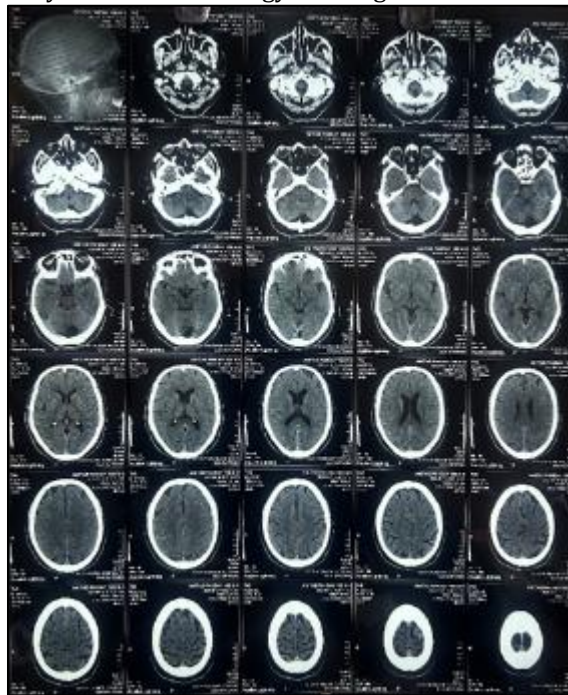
Non-Contrast Computed Tomography of Head – No abnormality detected
